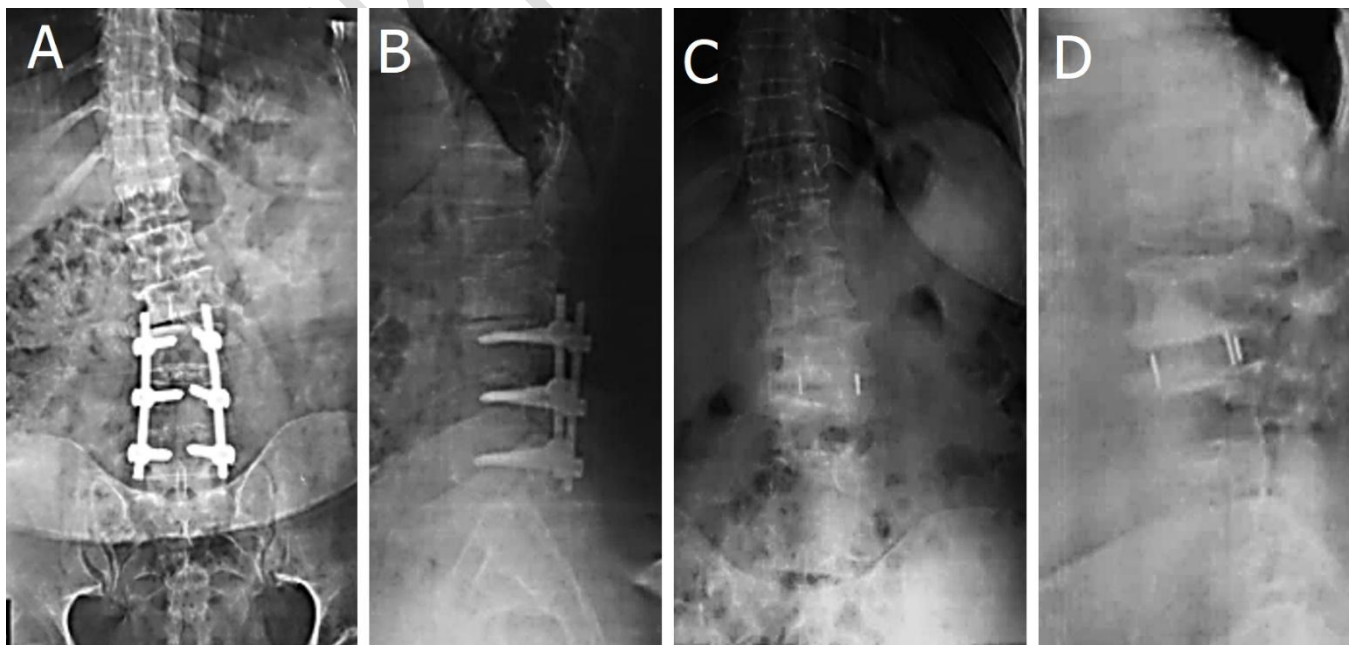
Case 1 a 45 years old female presented with back pain and right lower limb pain of 24 months duration. Back pain is increasing in intensity and aggravated by sitting, standing and relieved by analgesics. Right lower limb pain is found at rest and increased by walking. A: Pre-operative AP L/S X-ray Cobb angle was 15.5 degrees. B: Pre-operative Lat. L/S X-ray shows *SVA*: 13 mm, *PT*: 25 degrees, *PI*: 53 degrees, *SS*: 28 degrees, *LL*: 16 degrees, *PI/LL mismatch*: 37 and *anterior disc height*: 6.2 mm. C: AP L/S X-ray 1-year follow up *Cobb angle* 6 degrees, Sugrimap software A. *Cobb angle* in AP X-ray is 15.5 pre-operative. B. Post-operative follow up in 1-year period with *Cobb angle* 6. D: Lat. L/S X-ray 1-year follow up shows *SVA*: 8 mm, *SS*: 29 degrees, *PT*: 24 degrees, *LL* 21 degrees, *anterior disc height*: 8.1 mm and *PI/LL mismatch*: 32.
